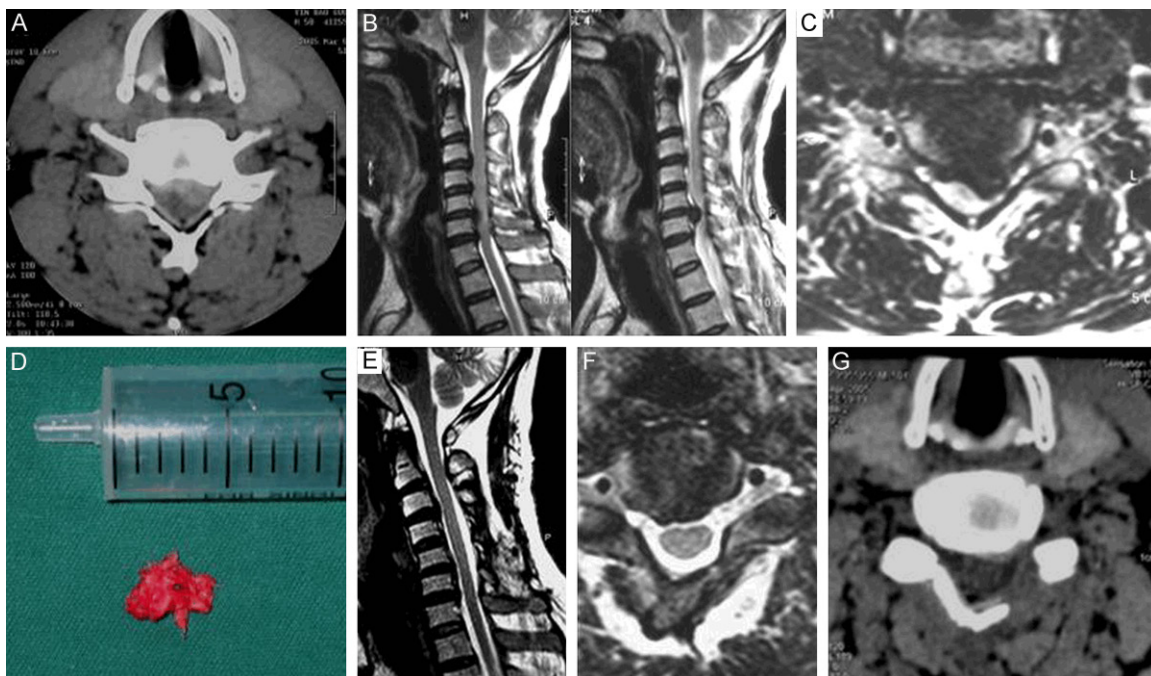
A: CT scan showing C5/6 disc herniation; B: MR image showing cervical stenosis associated with C5/6 disc herniation; C: MR image showing C5/6 disc herniation; D: Posterior removed C5/6 disc fragments; E: MR image showing complete anterior and posterior decompression of spinal cord after surgery; F: Postoperative MRI scan showing complete removal of C5/6 protruded disc fragment; G: Postoperative CT scan showing complete removal of C5/6 protruded disc fragments.
